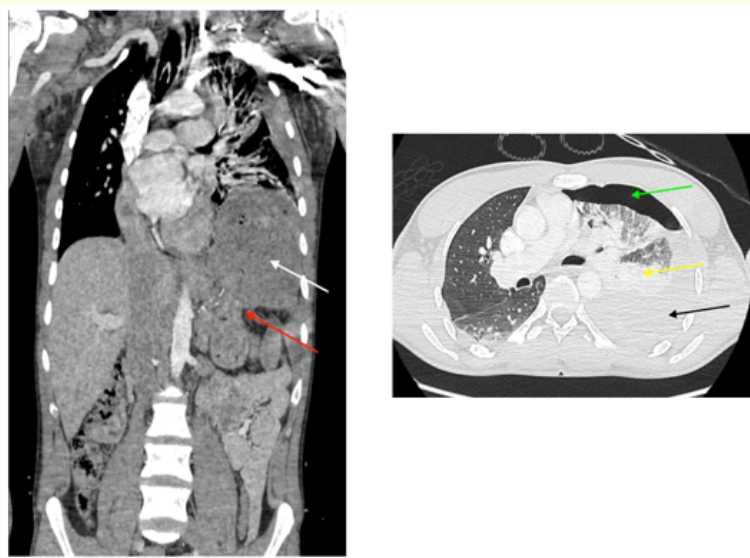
Contrast-enhanced thoracoabdominal CT findings of traumatic left diaphragmatic rupture with intrathoracic gastric herniation.
